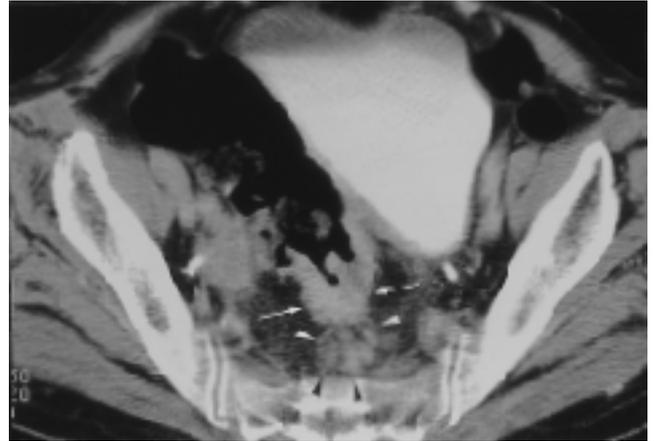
Air enema CT scan shows irregular sigmoid colonic wall thickening(arrow). Multiple enlarged lymph nodes(arrowheads) larger than 1cm are identified(N2). Pathologic study revealed five metastatic lymph nodes of 18 dissected pericolic lymph nodes (N2).
